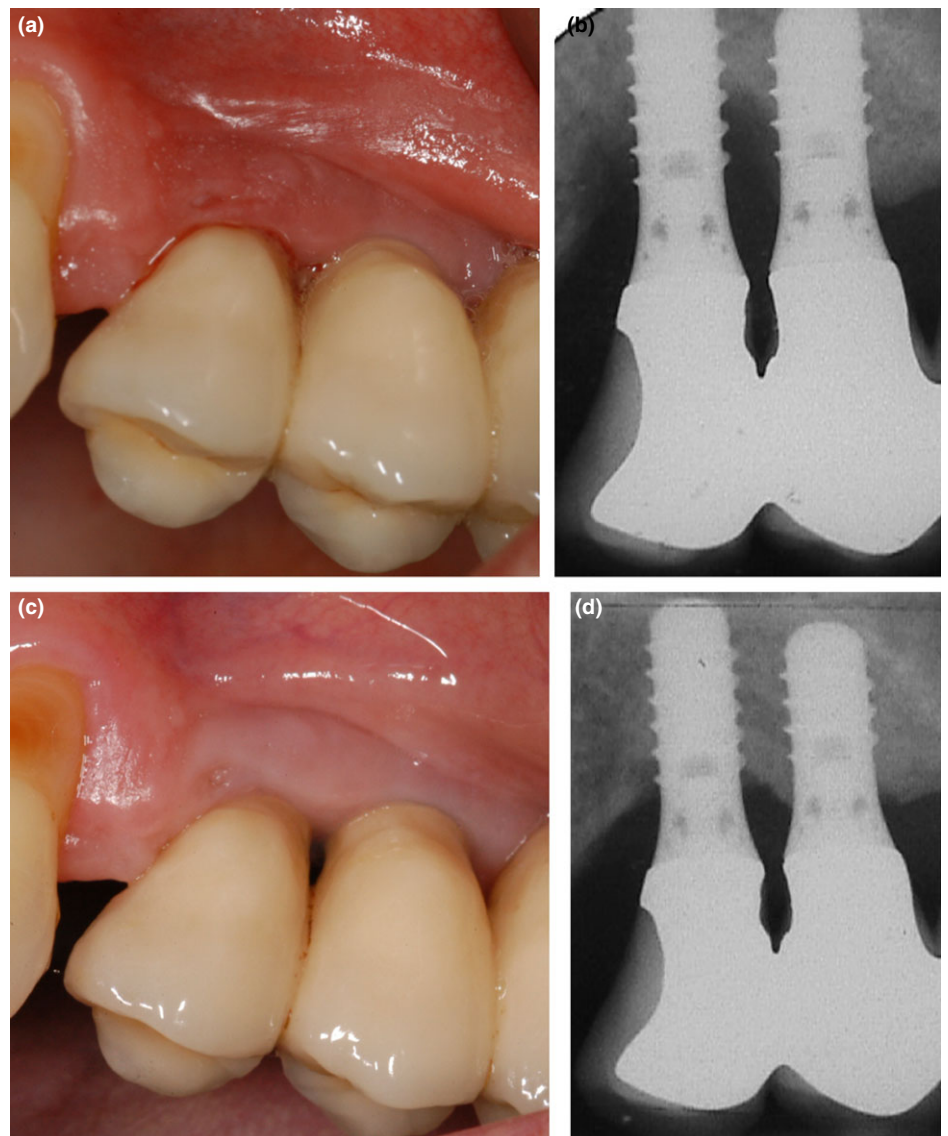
Baseline view of implants 24 and 25 with PPD ≤ 8 mm, bleeding on probing (BoP) and suppuration (a); baseline radiographic bone defect at implant 24 and at the mesial aspect of implant 25 (b); buccal view of implants 24 and 25 at the 2-year follow-up with PPD ≤ 4 mm (c); radiographic hard tissue fill at the 2-year follow-up at implant 24 and at the mesial aspect of implant 25 (d).
